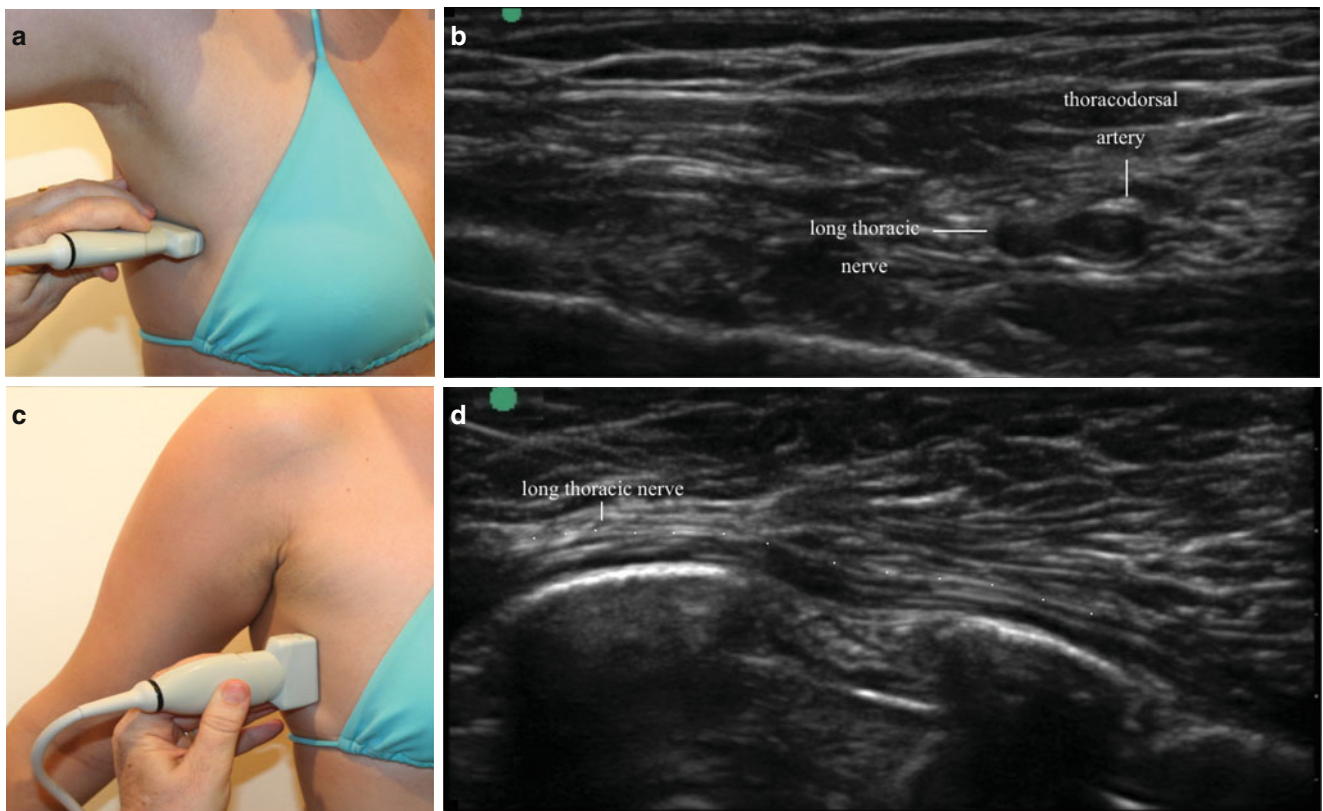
Ultrasound of long thoracic nerve at the axilla. The nerve is first imaged with the probe horizontal (a, b), and then the probe is rotated vertically to image the ribs more clearly (c, d) (Image courtesy of Andrea Trescot, MD)
